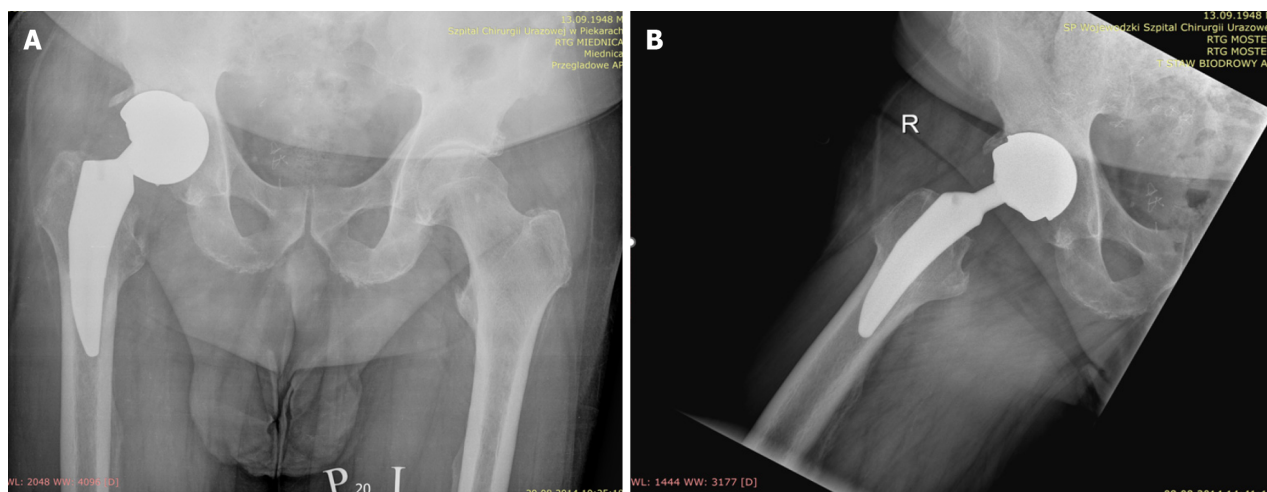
X-ray images of total right hip endoprosthesis acetabular component loosening. A: Right hip joint; B: Right hip joint in lateral view.
